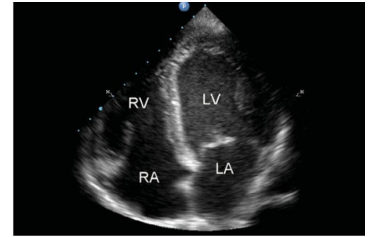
Normal apical four-chamber view. RV, right ventricle; LV, left ventricle; RA, right atrium; LA, left atrium. (Reproduced, with permission, from Carmody KA, et al: *Handbook of Critical Care and Emergency Ultrasound*. McGraw-Hill, 2011.)
